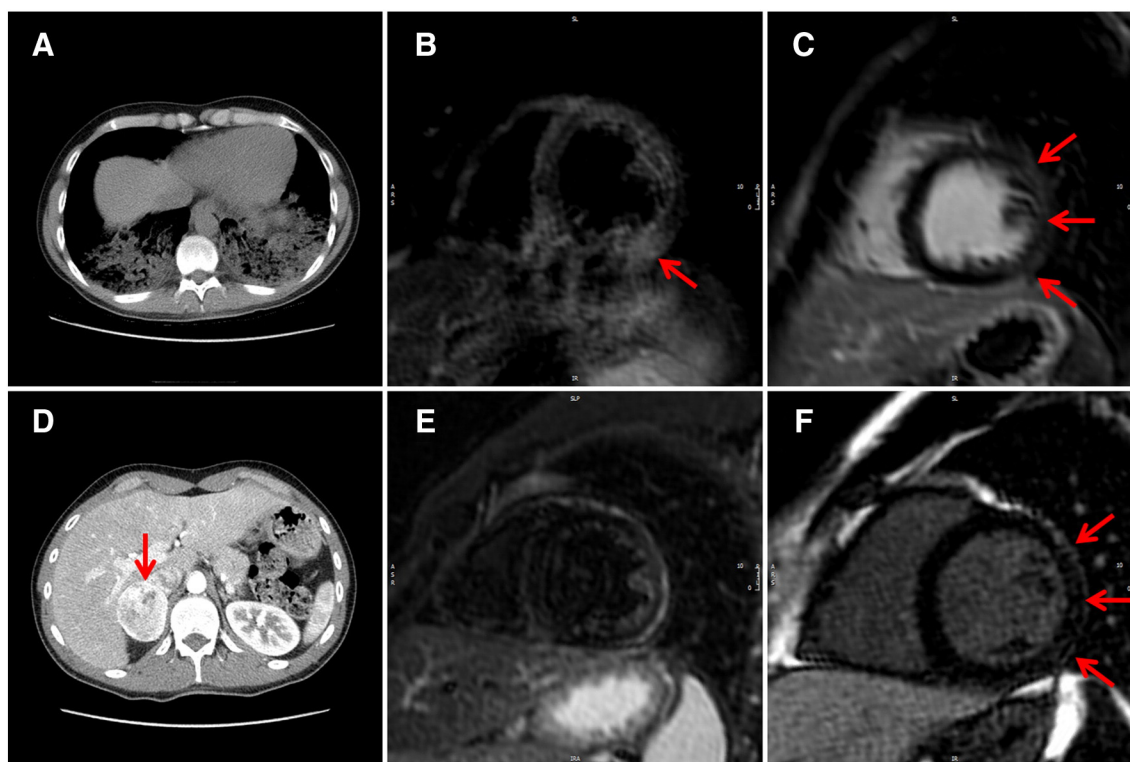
A, Thoracic CT scan showing bilateral airspace consolidations in the posterior pulmonary quadrants. B, T_2 -weighted imaging by basal CMR demonstrating regional myocardial edema of the inferolateral wall of the left ventricle (red arrow). C, Subepicardial LGE in the inferolateral and anterolateral walls (red arrows) in a postcontrast T_1 -weighted image. D, Abdominal contrast-enhanced CT scan showing a voluminous mass in the right adrenal gland (red arrow). E, T_2 -weighted imaging by follow-up CMR demonstrating the resolution of previously detected myocardial edema. F, Postcontrast T_1 -weighted image showing limited residual LGE (red arrows).
